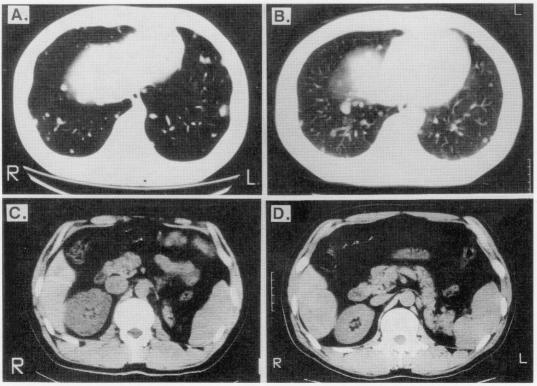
The computed tomography of the chest (A, B) and the abdomen (C, D). Left (A, C); the CT scans were taken in 1983. Right (B, D); the CT scans were taken in 1990. Multiple metastatic lesions in lung are shown. The size of the tumor in liver increases.
